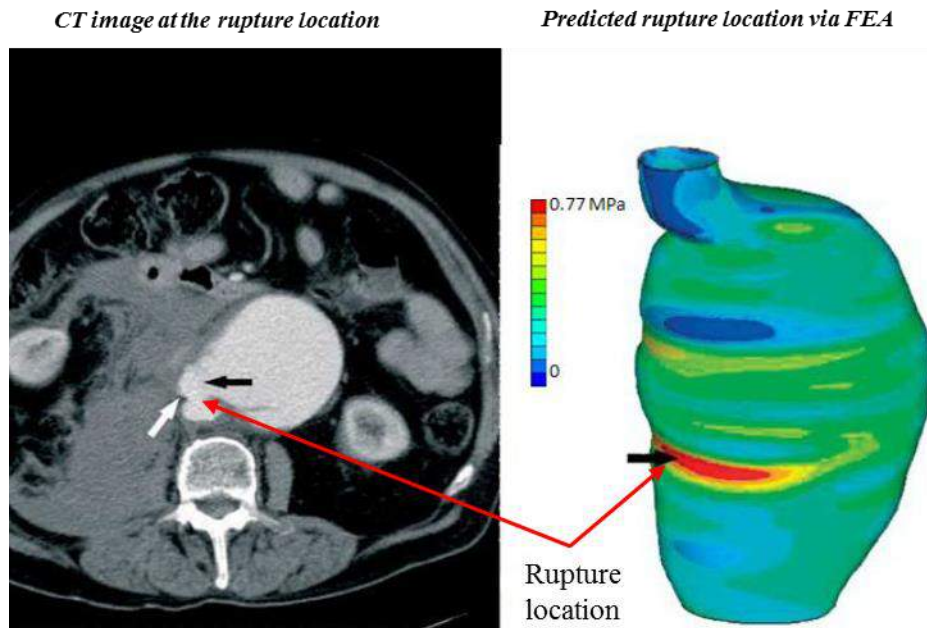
Demonstrates the site of rupture in a cross-sectional CT scan (Left); predicted high wall stress via the FEA model(Right). [84]
